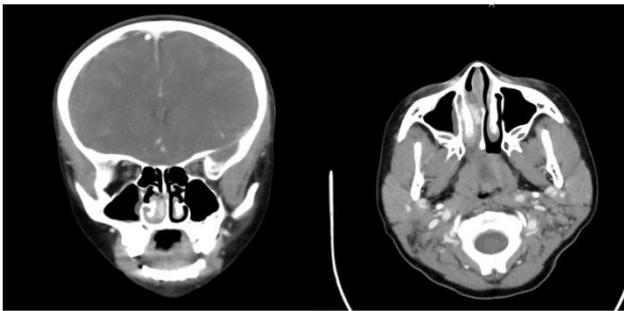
CT head and neck with contrast.
